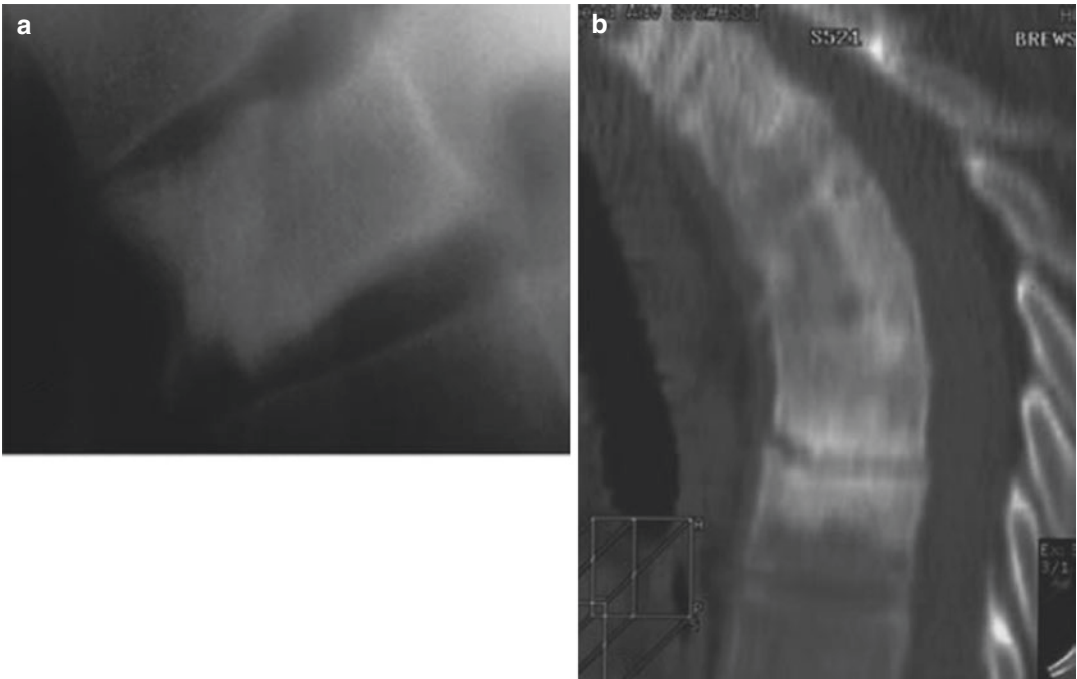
An 18-year-old male with SAPHO; sagittal tomogram (a) demonstrates T4 vertebral body sclerosis. A follow-up sagittal, reformatted CT of the thoracic spine (b) performed 17 years later demonstrates resolved T4
